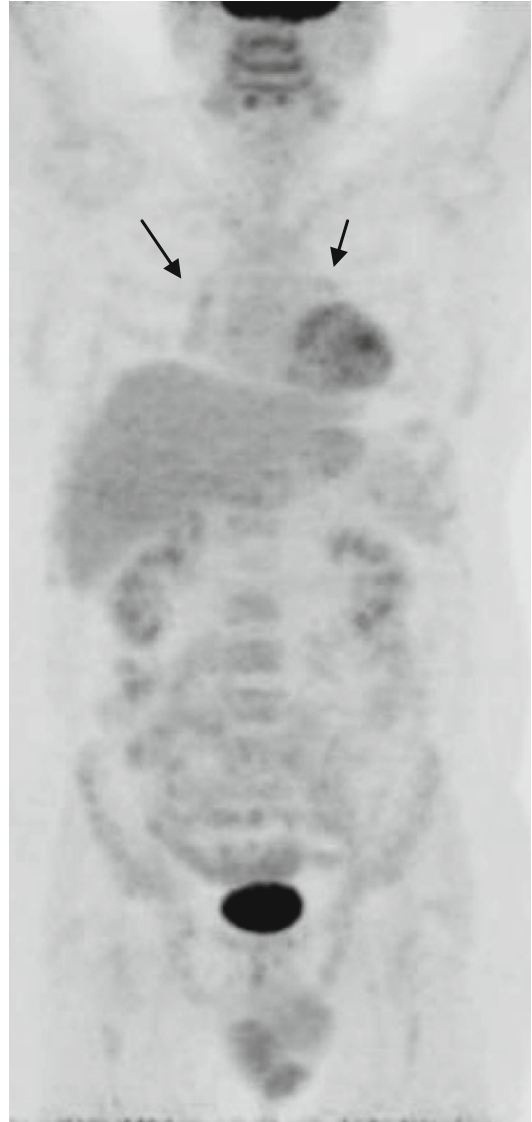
PET/CT after salvage chemotherapy. Faint, symmetric 18-FDG uptake (SUV max 2.5) in both lung hili (arrows)
